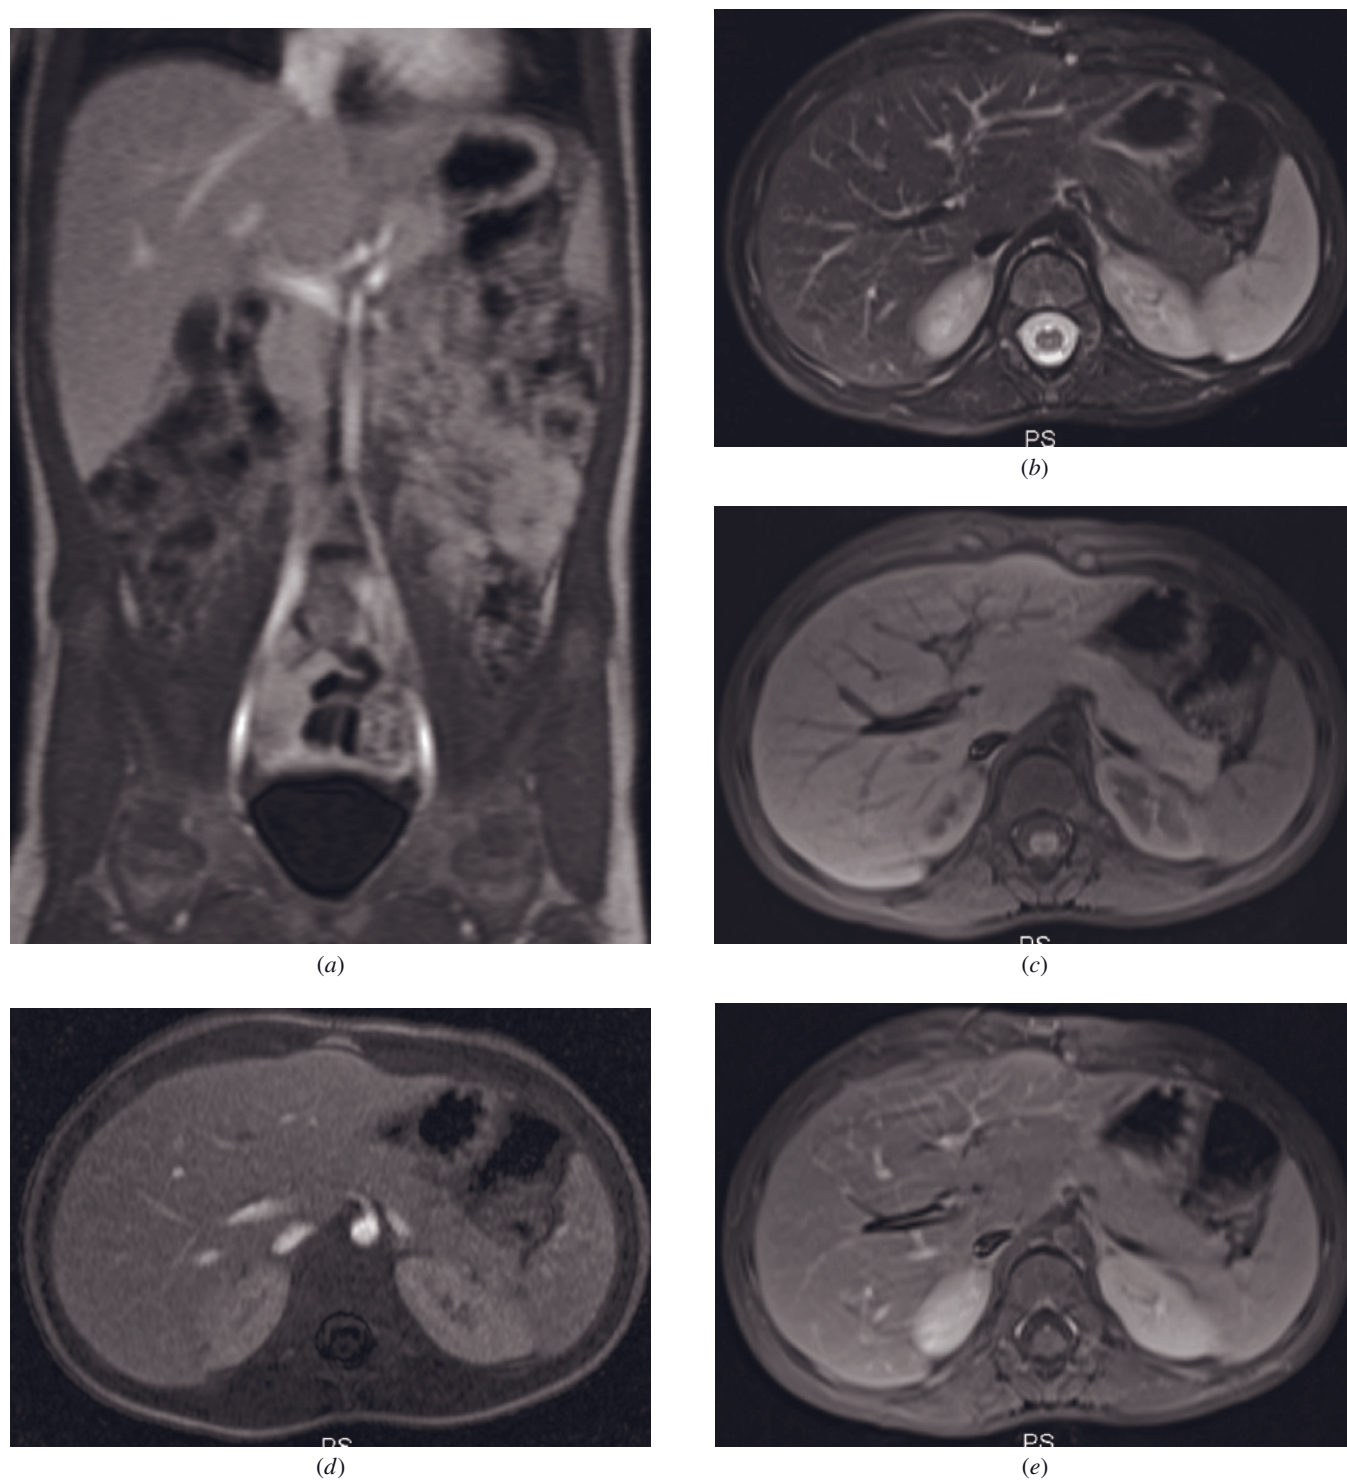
Breathing-averaged (sedated patient) protocol MRI of the abdomen in a 3-year-old female at 1.5 T. Coronal water-excitation MP-RAGE (*a*), axial T2-weighted breathing-averaged fat suppressed spin-echo (*b*), axial T1-weighted fat-suppressed spin-echo (*c*), axial immediate postgadolinium MP-RAGE (*d*), and interstitial-phase T1-weighted fat-suppressed spin-echo (*e*) images. Note that *d* has a grainier appearance than the same sequence at 3.0 T (see fig. 17.1*d*), reflecting the lower signal-to-noise ratio of MP-RAGE at 1.5 T. Motion-resistant protocol in a 2-year-old female at 3.0 T. Coronal T2-weighted single-shot echo-train
